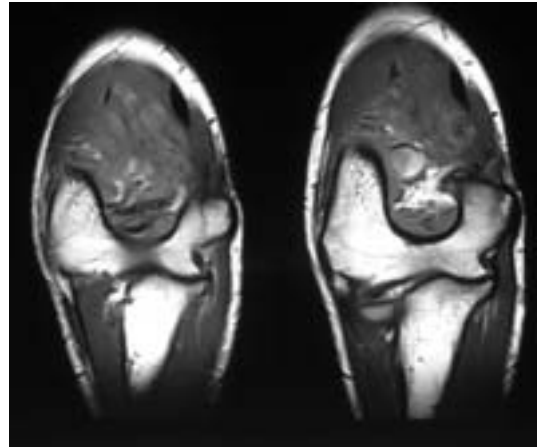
Axial T1-weighted fast spin echo image through the right elbow demonstrating a heterogeneous mass with low and intermediate signal areas within the joint
